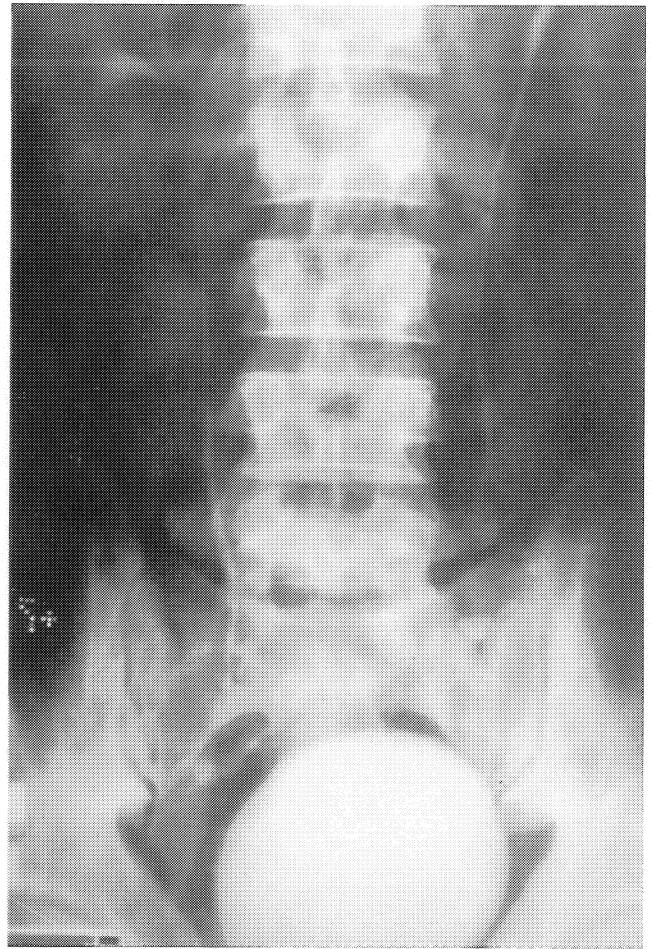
An anteroposterior roentgenograph of the lumbosacral spine at time of intravenous pyelogram reveals granular irregularities with mixed osteosclerosis and osteolysis.
